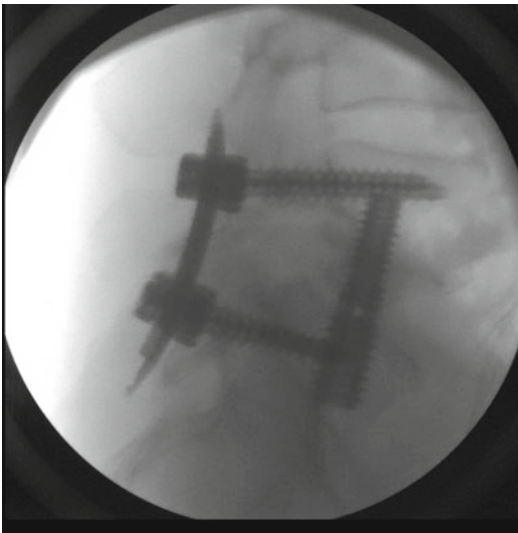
Intraoperative lateral x-ray demonstrating the completed minimally invasive construct of a L5–S1 interbody fusion via the presacral approach
